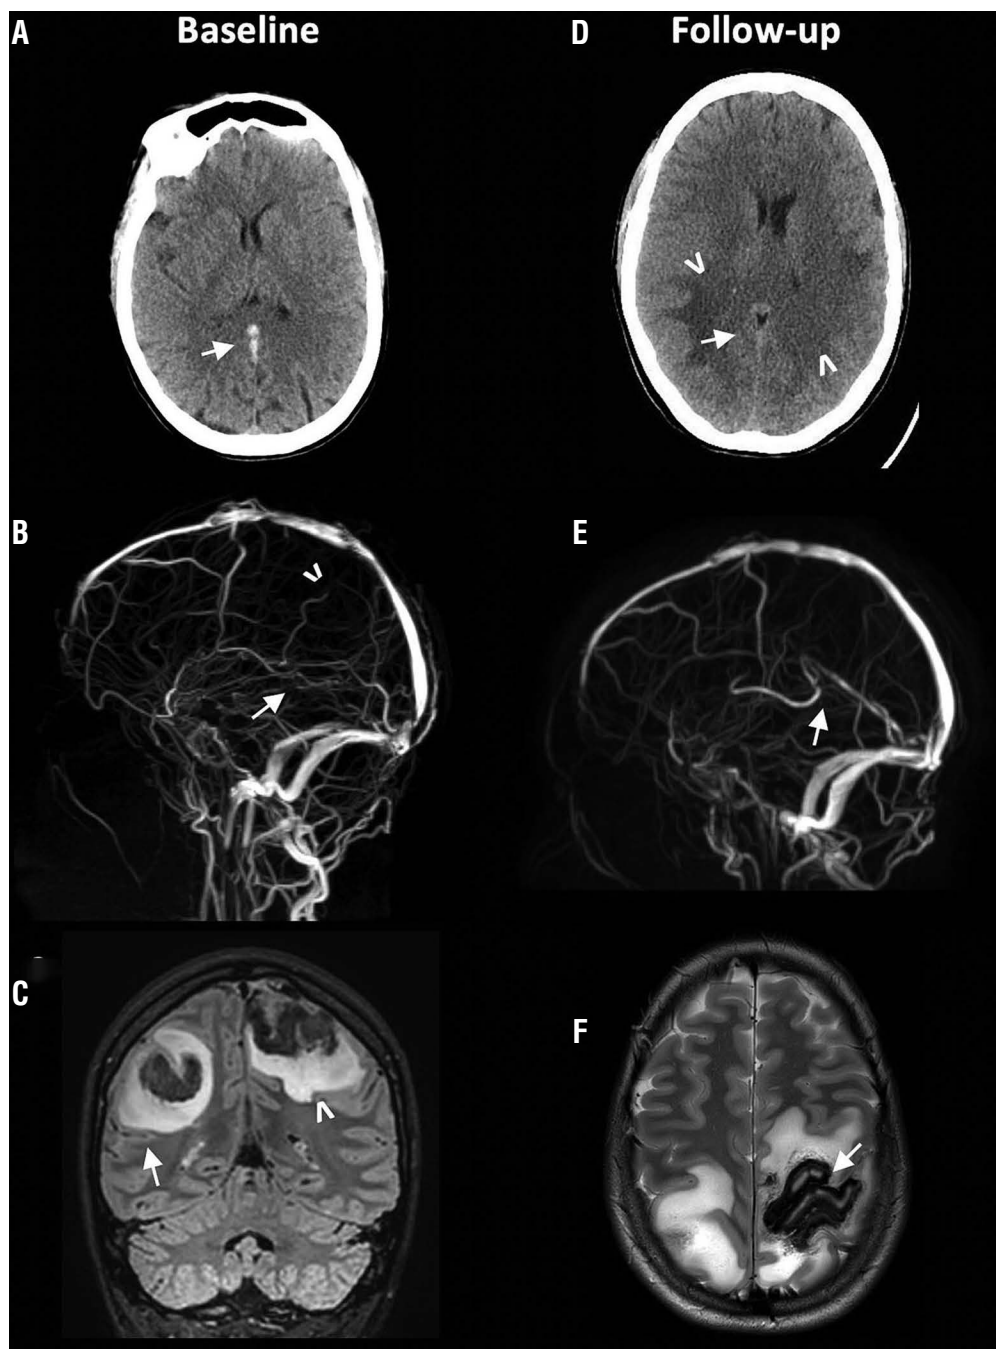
Neuroradiological findings at baseline and follow-up. (A) baseline computerised tomography (CT) (at admission) shows hyperdense rectus sinus and vein of Galen as signs of thrombosis (arrow). (B) Magnetic resonance imaging (MRI) examination (day 1) confirms complete occlusion of the rectus sinus, vein of Galen, right internal cerebral vein (arrow) and frontoparietal cortical veins on both sides (arrow head) on venous angiography. (C) On coronal T2-FLAIR images extensive venous infarctions with hemorrhagic transformation can be seen in right parietal (arrow) and left frontoparietal (arrow head) regions. (D) On follow-up CT (day 6) rectus sinus and vein of Galen show normal density (arrow) with oedema in brain tissue on both hemispheres (arrow head). Follow-up MRI (day 7) shows (E) restored venous flow in the rectus sinus and the vein of Galen (arrow); right internal cerebral vein and bilateral frontoparietal cortical veins are still occluded. (F) On T2 weighted images the large bilateral venous infarctions are still visible with hemorrhagic transformation in pre- and postcentral gyrus in the left side (arrow).
